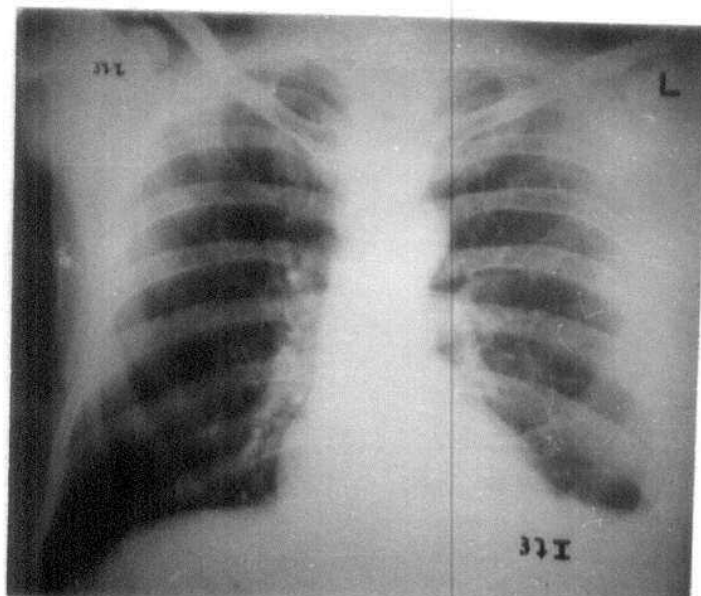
postoperative chest radiograph for patient No. 37 I (24 hours after surgery): showing left sided pleural effusion.
